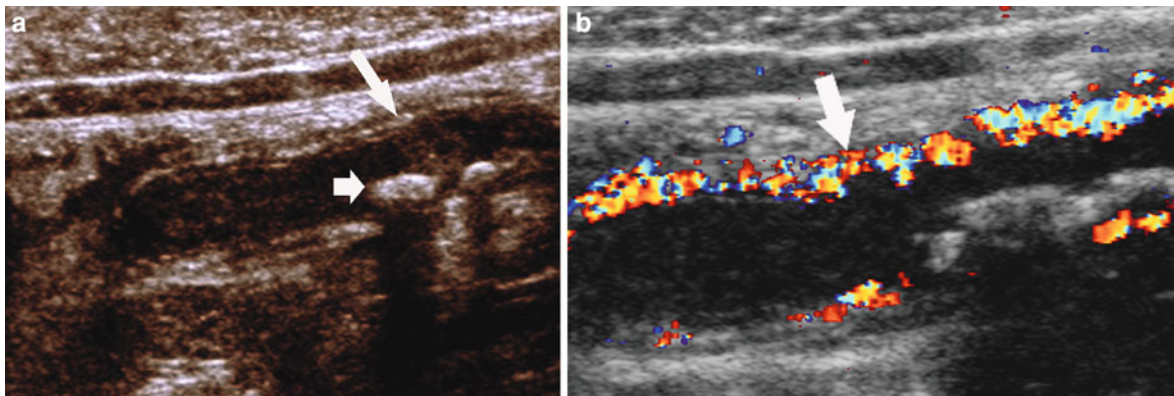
a, b Value of color Doppler in establishing diagnosis of early, uncomplicated acute appendicitis. a is graded-compression grayscale long-axis sonogram of appendix demonstrating preservation of normal echogenic submucosal line (*long white*
